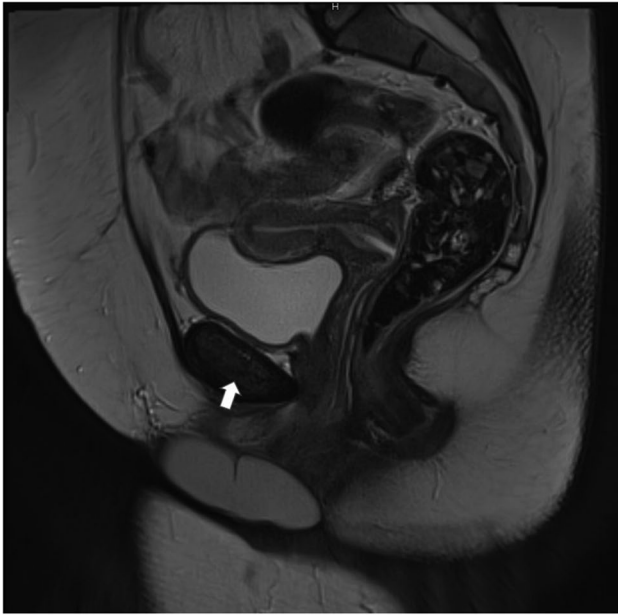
MRI sagittal view of clitoral cyst
